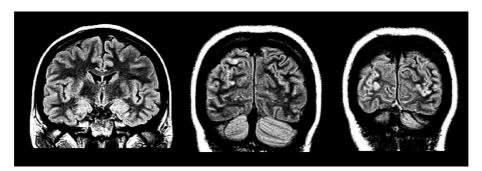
Hippocampal and cerebral subarachnoid lesions on MRI. FLAIR imaging showed hyperintense lesions in the medial temporal lobes and the cerebral subarachnoid region.
